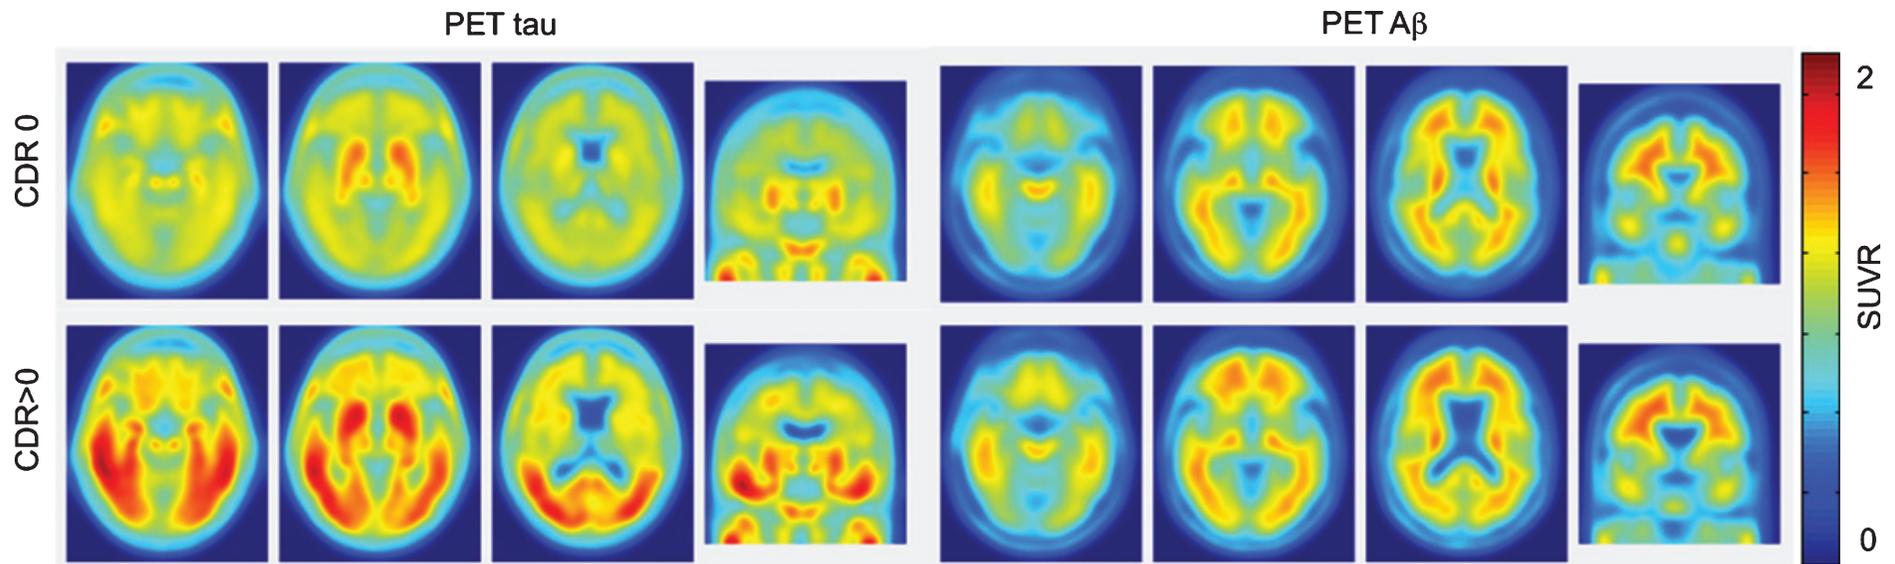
Tau and A β PET images in cognitively healthy controls (top-CDR0) and AD patients (bottom-CDR>0). Notice that tau deposition is a better predictor of cognitive decline than A β deposition. Figure reprinted with permission from [73]. CDR, Clinical Dementia Rating; SUVR, standardized uptake value ratio.
